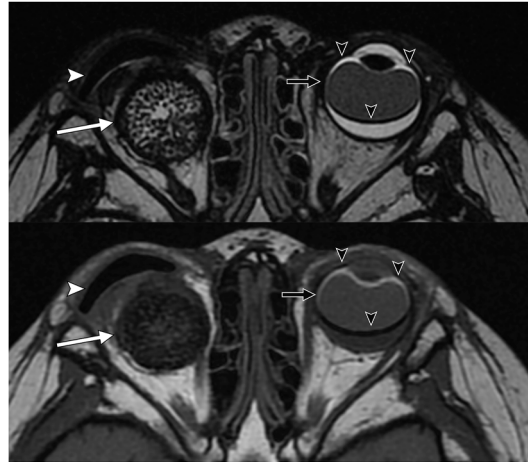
Axial T2-weighted (top) and T1-weighted (bottom) MR sequences demonstrating a right porous orbital implant (white arrow) and ocular prosthesis (white arrowhead). Left intraocular silicone oil shows T2-weighted hypointense and T1-weighted hyperintense signal (black arrows). Note chemical shift artifacts at the oil-fluid interface (black arrowheads).
